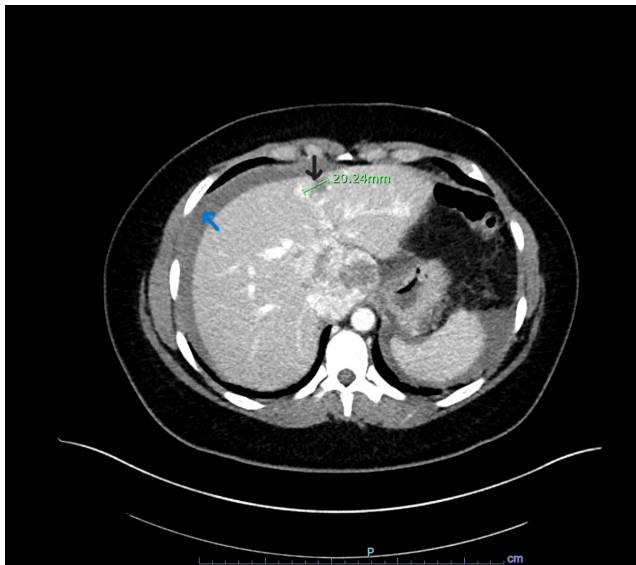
CT of the abdomen and pelvis with IV contrast: one (black arrow) of five heterogeneously enhancing hepatic lesions suspicious for metastases. The blue arrow points to the hemoperitoneum.
